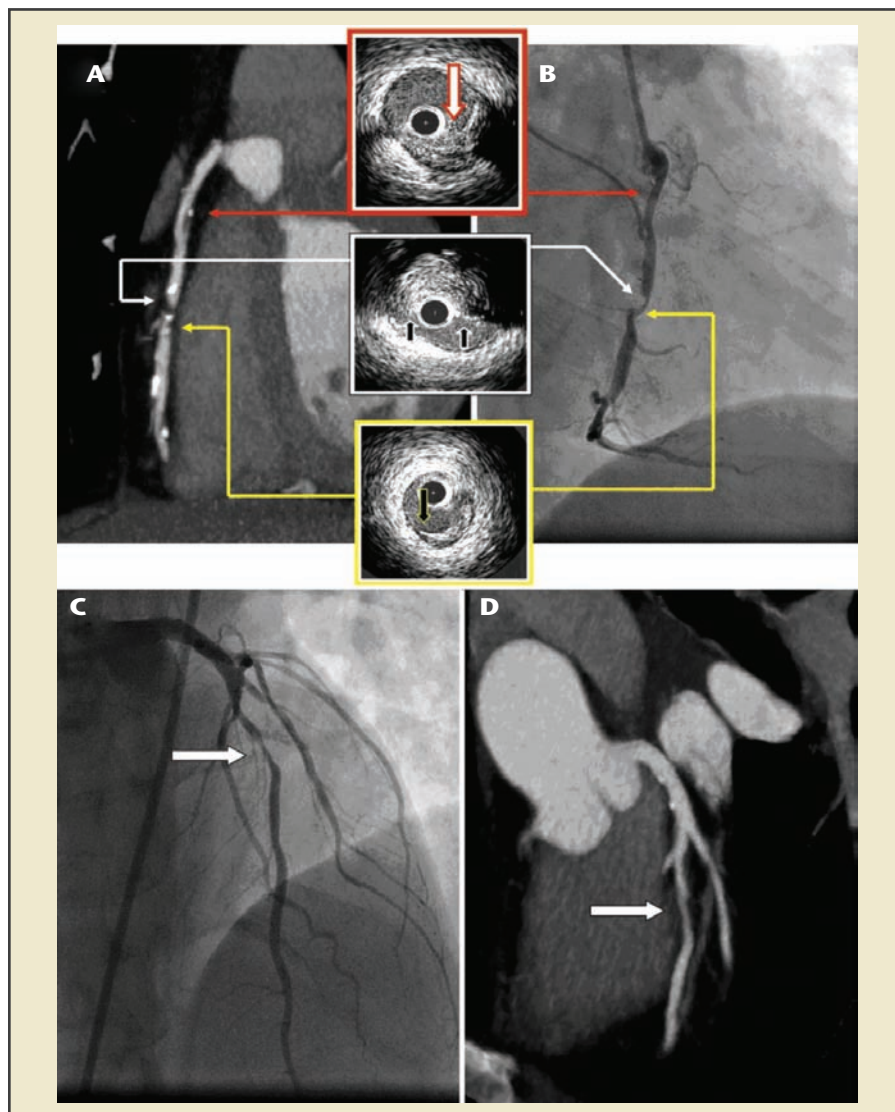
Putative computed tomography (CT) differences between unstable and stable plaque in the same patient. The coronary computed tomography (CCTA) image (A) documents an ulcerated, bulky, eccentric, hypodense mid-right circumflex artery (RCA) lesion; intravascular ultrasound confirms complex morphology with bulky, eccentric, disrupted plaque in the proximal (middle box, white arrows) and distal (lower box, yellow arrows) aspects of this lesion. Invasive angiography (B) reveals a concordant bulky, eccentric, scalloped complex RCA lesion (white and yellow arrows). Proximally to the culprit lesion, CCTA documents a bulky, eccentric, hypodense lesion (red arrows) confirmed by intravascular ultrasound (upper red box), which is less apparent by invasive imaging. An invasive angiogram (C) demonstrates noncomplex stenotic plaque in the mid-left anterior descending coronary artery (white arrow). The CCTA image (D) similarly reveals noncomplex plaque lacking the bulky, hypodense disrupted features characteristic of complex plaques. Reprinted with permission from O'Neil B, Gallagher MJ, Raff GL, "Use of multislice CT and MRI for the evaluation of patients with chest pain," In: Peacock WF, Cannon CP, eds, *Short Stay Management of Chest Pain*, New York; Humana Press: 2009;185-203.²⁶
